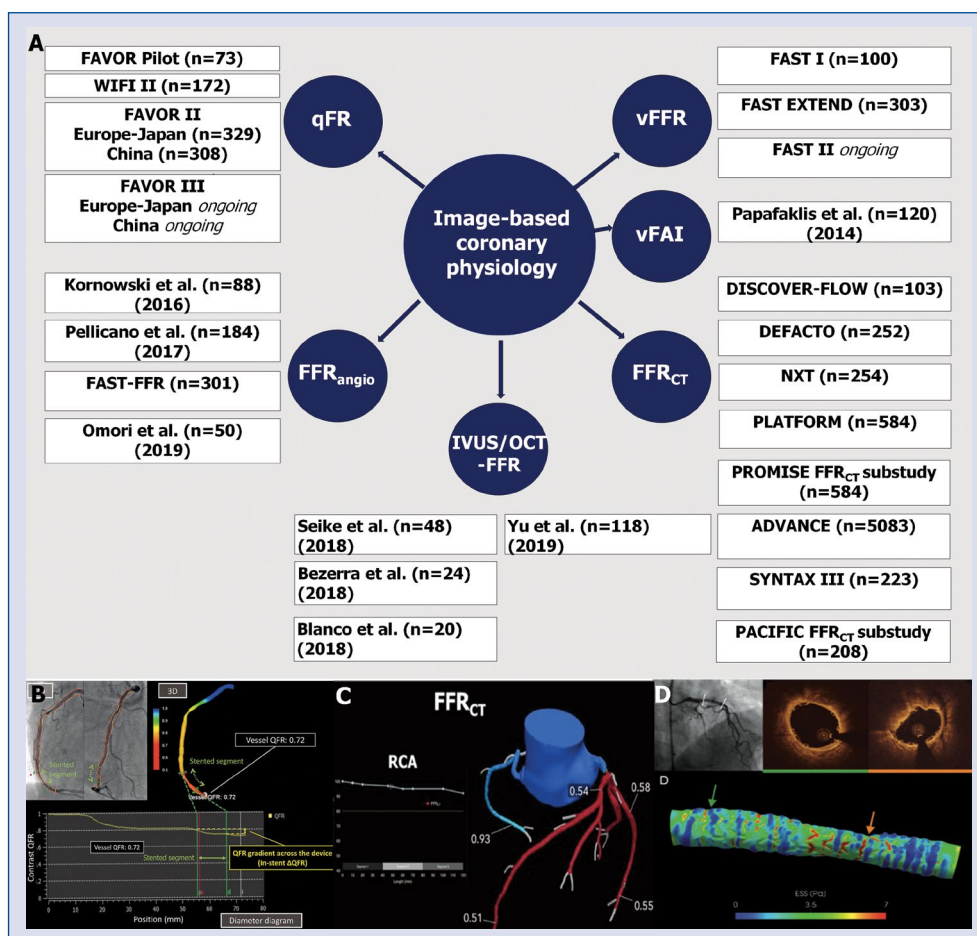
Imaging-based coronary physiology assessment; A. Graphic summary of imaging-based modalities for functional evaluation of coronary stenosis; B, C. Examples of quantitative coronary angiography- and computed coronary tomography angiography-based fractional flow reserve estimation; D. Computational fluid dynamics for wall shear stress computation; qFR — quantitative flow ratio; vFFR — vessel fractional flow reserve; FFR_{angio} — fractional flow reserve derived from angiography; vFAI — virtual functional assessment index; FFR — fractional flow reserve; IVUS — intravascular ultrasound; OCT — optical coherence tomography; RCA — right coronary artery. Adapted with permissions from: Asano T et al. *EuroIntervention*. 2018; 14: 570–579; Modolo R et al. *Ann Cardiothorac Surg*. 2018; 7: 470–482; Thondapu V et al. *Eur Heart J*. 2018; 7: 1602–1609.
